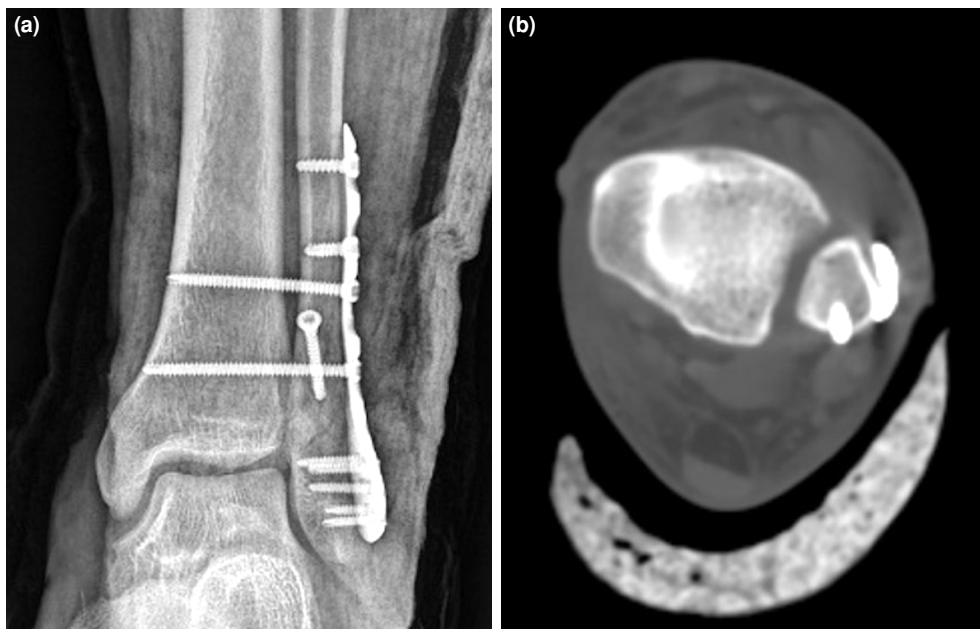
Post-revision ankle AP radiograph and CT scan. (a) Post-revision AP radiograph displaying syndesmosis screw fixation. (b) Computed tomography axial section scan after revision surgery. AP: Anteroposterior; CT: Computed tomography.
